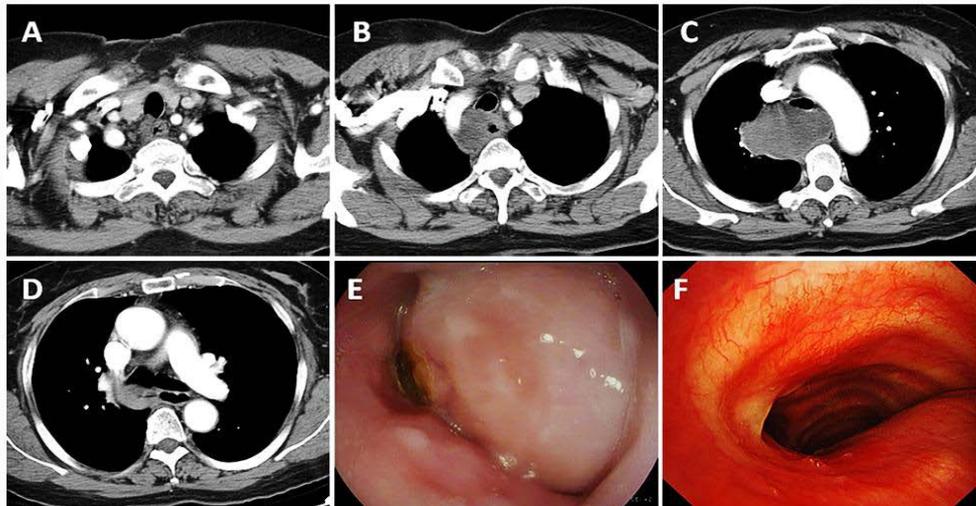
(A-D) Chest CT scan showing an irregular mass in the right posterior upper mediastinum. The mass is close to the right brachiocephalic vein, superior vena cava, right upper pulmonary artery, and azygos vein. (E) Esophagoscopy image showing that the esophageal mucosa is swollen and the upper lumen is narrowed. (F) Bronchoscopy images showing an external pressure-induced bulge in the middle and lower part of the trachea and the opening of the right main bronchus.
